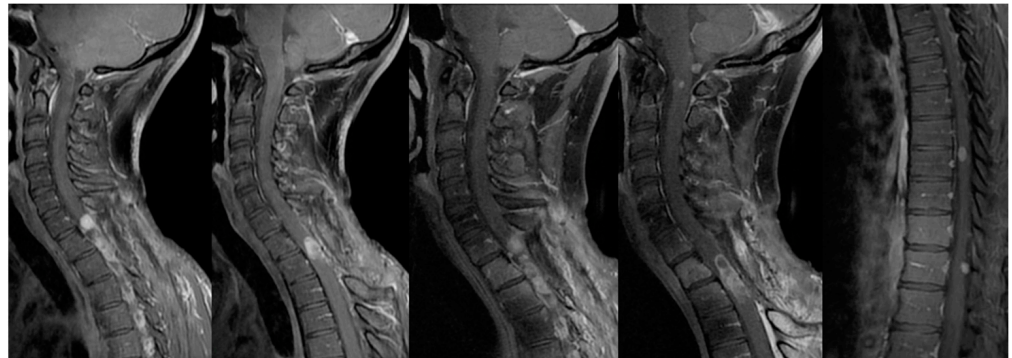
MRI at 11 months post-operation in sagittal contrast-enhanced T1-weighted images showing the progression of disease at different cervical tracts, and smaller additional intradural enhancing nodules along the surface of the tonsil of cerebellum, in the medulla oblongata, and in the lower thoracic spinal cord.
